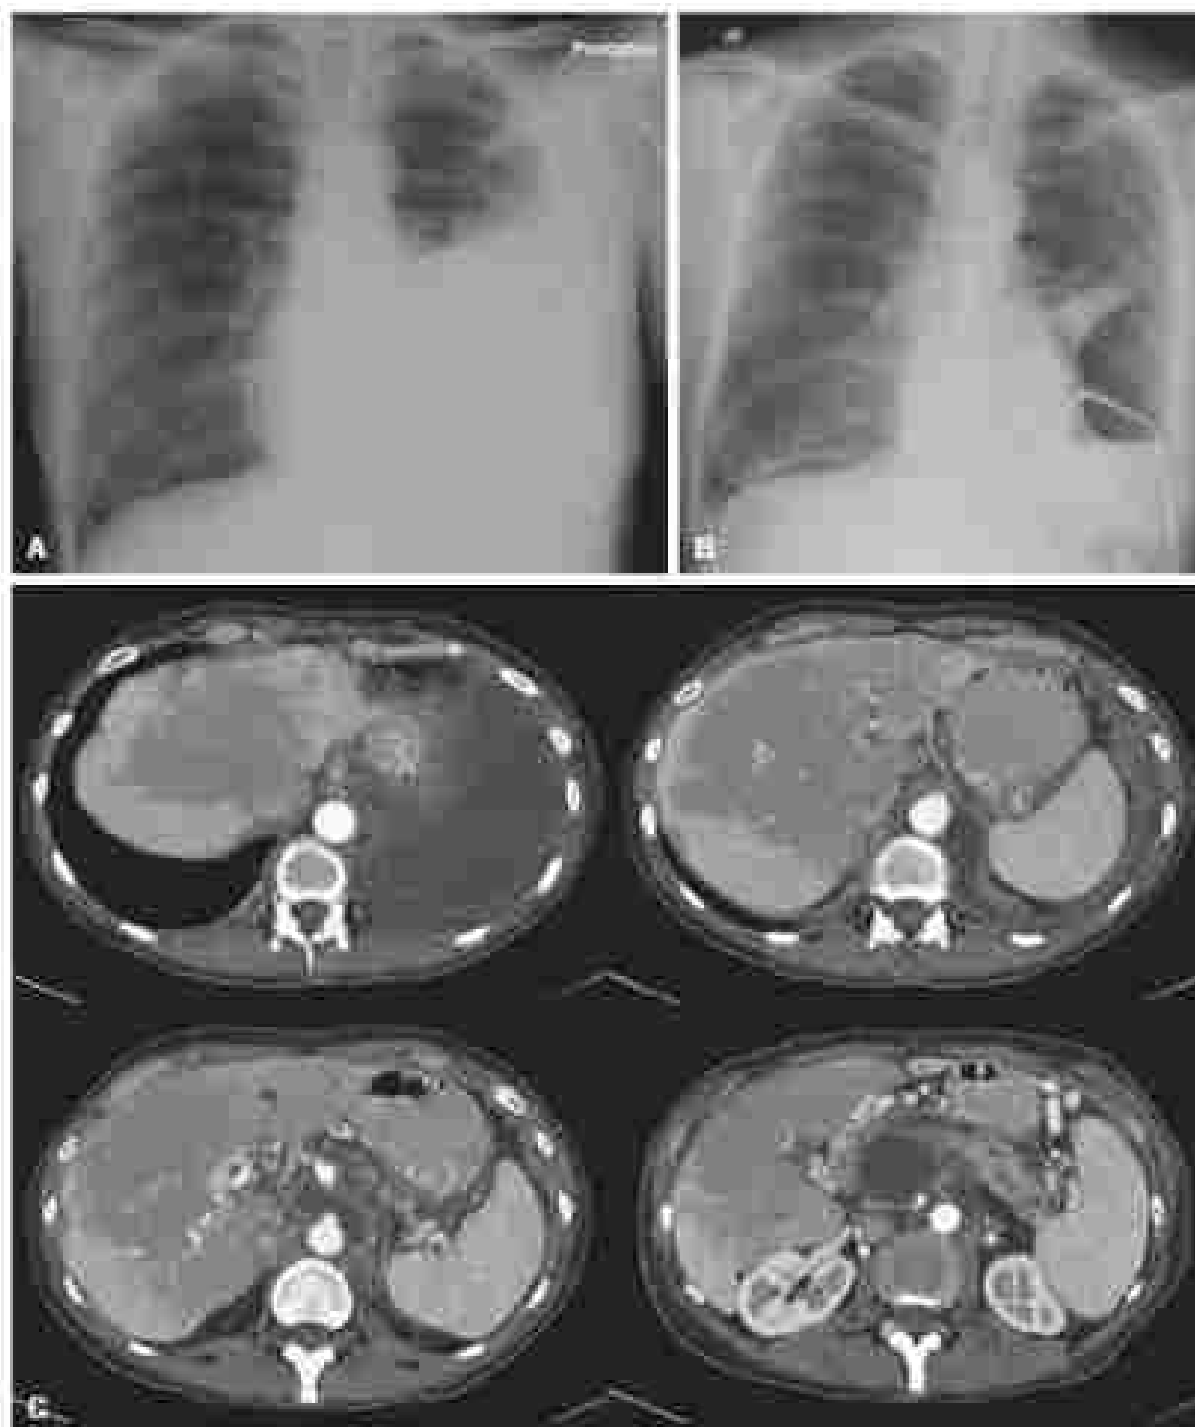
Patient with a pneumothorax, pleural effusion, and bleed. (A) Initial chest radiographic demonstrates spontaneous pneumothorax of the left middle and lower lung zones consistent with moderate spontaneous pneumothorax. (B) After medical drainage of the left pleural effusion, there was a left lower hydropneumothorax with a dense surrounding ground glass consistent with a trapped left lung. In addition, a curvilinear lucency was seen under the right hemidiaphragm representing intraperitoneal air following a laparoscopy to address the bleed. (C) Preoperative computed tomography scans demonstrate evidence of chronic pancreatitis with peripancreatic cystic consolidation and pseudocysts. One such pseudocyst extends superiorly into the left upper abdomen, where it communicates with the pleural space. A large left pleural effusion is associated with the finding. Other findings include portal vein dilatation, splenic vein pseudocyst, and a 1.8-cm splenic artery aneurysm.
